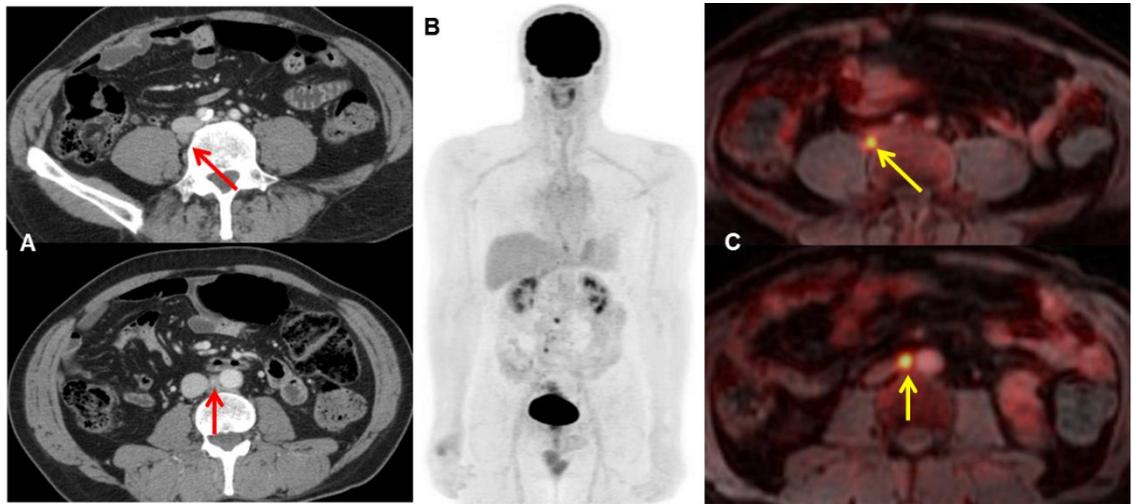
PET/MRI is superior to CS for upstaging from M0 to M1 in non-regional lymph nodes and for clarifying indeterminate lesions detected by CS. The patient was a 64-year-old man, and PET/MRI revealed two small (< 1 cm) indeterminate retroperitoneal lymph nodes (A; red arrows) that were considered positive due to high FDG uptake. The interaortocaval lesion was biopsied and confirmed as metastatic adenocarcinoma.
